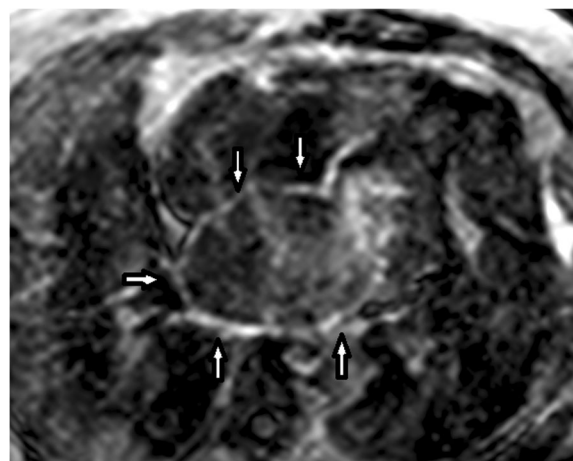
DE-MRI showing severe left atrial fibrosis (circumferential, arrows)
